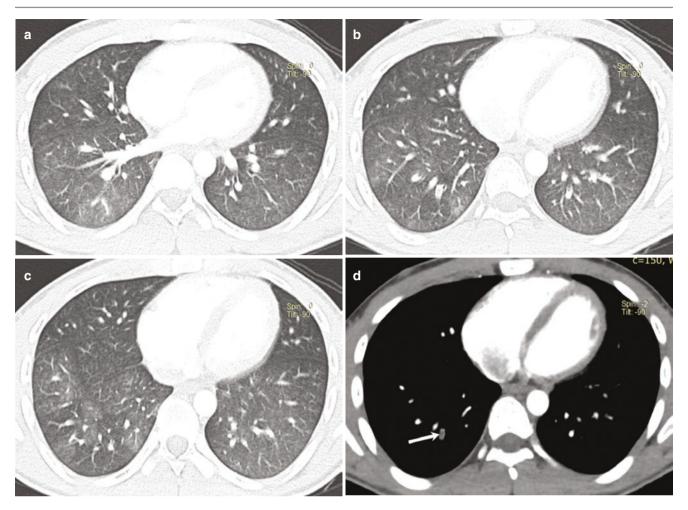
A 27-year-old man with fat embolism immediately after internal fixation of the femoral fracture. The patient developed dyspnea, petechial skin rashes, and altered mental status. (a–c) Axial CT images
